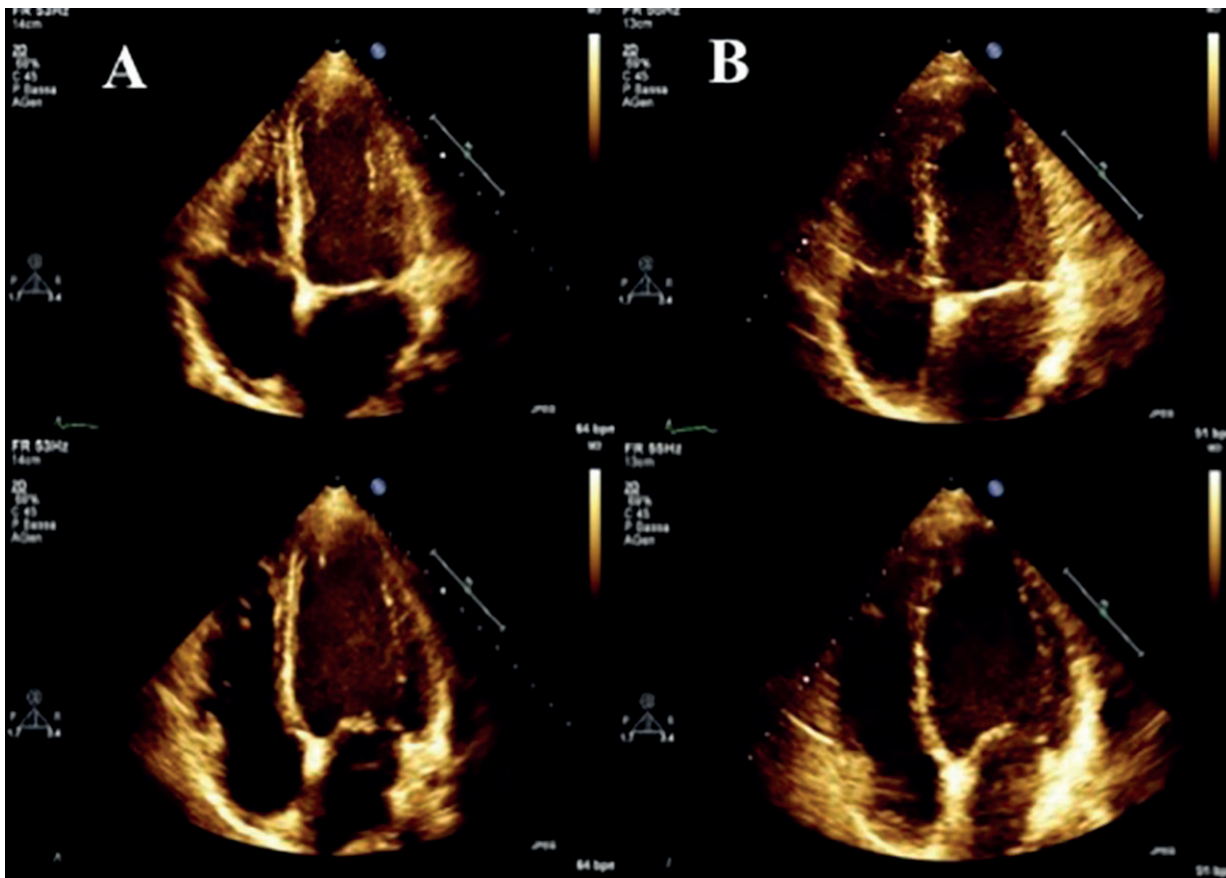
Echocardiogram. A, The apical four chamber view shows an apical ballooning in end-systole. B, After 1 month, recovery of ventricular shape.
